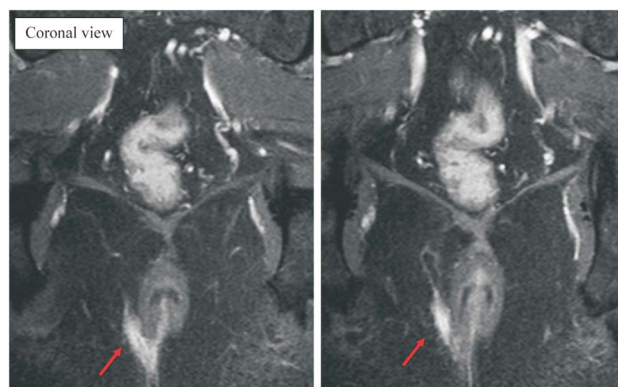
Coronal MRI of the pelvis in a 64-year-old male (Patient A) with a suprasphincteric anal fistula (arrow site).
